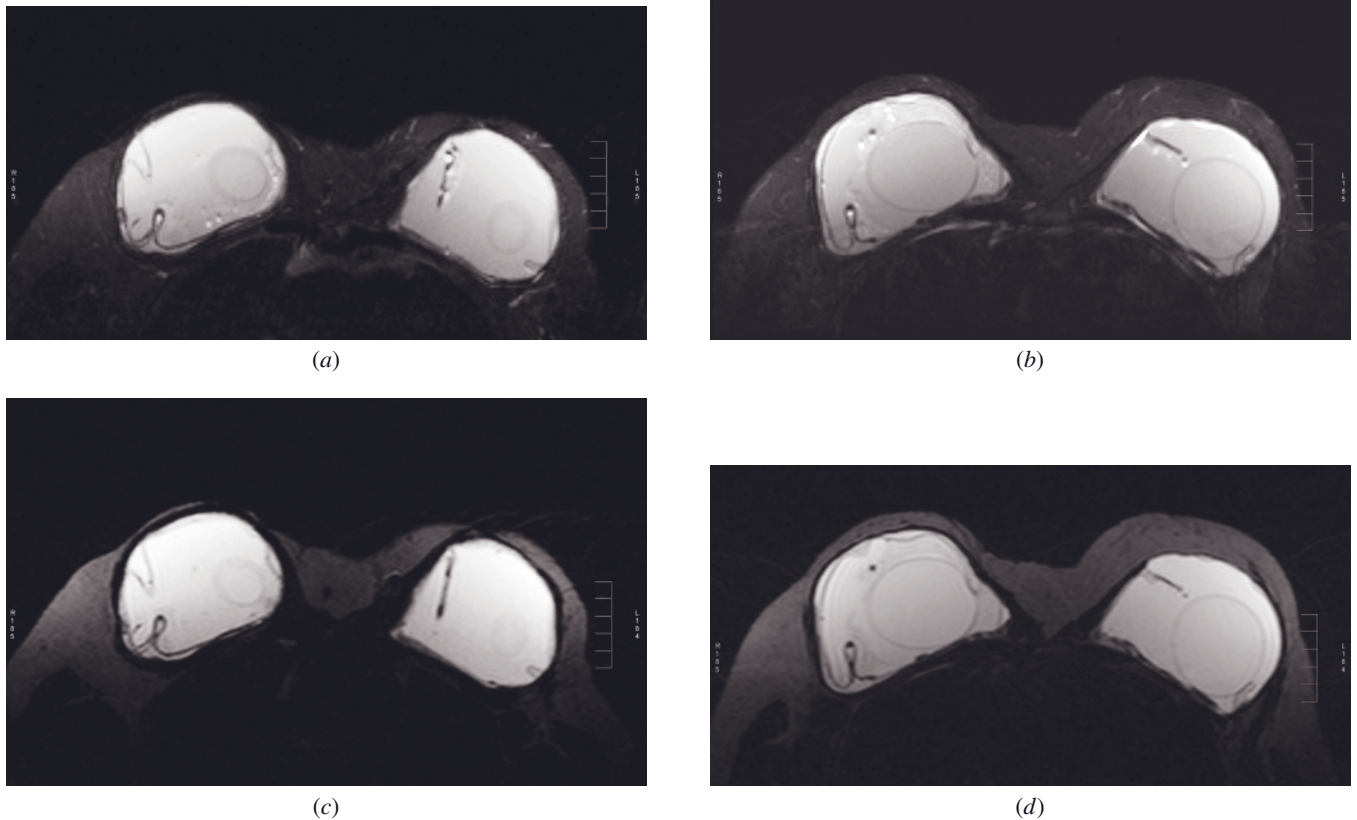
Intracapsular rupture of outer lumen of double-lumen silicone-silicone implants. Bilateral axial fat-saturated T2-weighted (*a, b*) and corresponding silicone-specific (*c, d*) images demonstrate various signs of implant rupture. Keyhole sign is seen in the posterolateral aspect of the right breast implant, while there is a noose sign in the same area on the opposite side. There is pull-away sign in the anterolateral aspect of the right breast implant. Salad-oil sign is also seen as high signal foci within the gel (*a, b*), which are suppressed on silicone-only sequences (*c, d*), indicating fluid/serum influx, likely through a defect capsule. Note the rounded shape of the inner lumen components bilaterally, reflecting higher silicone pressure within them, which is a normal finding.
